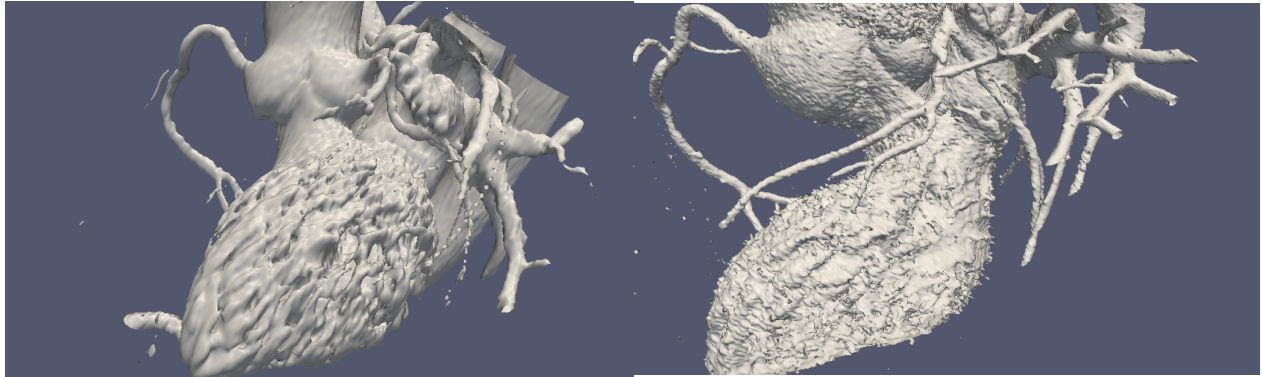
Isosurfaces of CT images using FBP (left) and IR (right).
